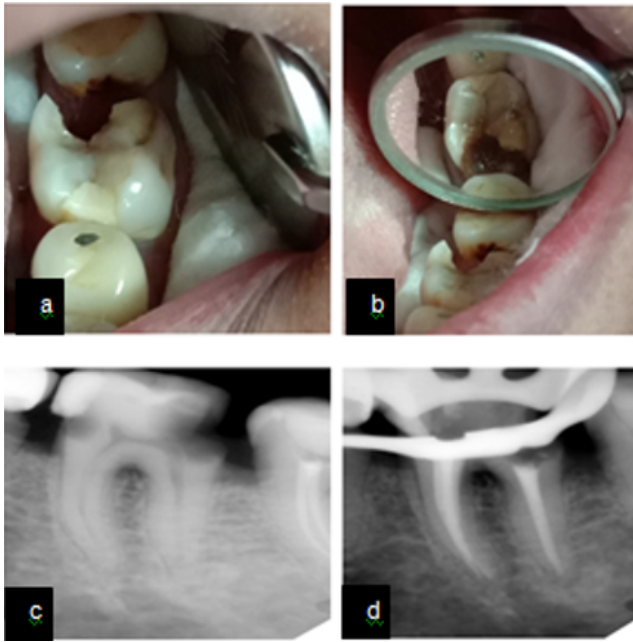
Tooth number 36 showing fractured restoration distally w.r.t 36. Caries detected below contact point of restoration on mesial aspect; a,b: Pre operative radiograph revealed radiolucency distally approximating pulp and radiolucency mesially below the restoration suggestive of secondary caries. Widening of periodontalligament w.r.t 36; c: Post obturation radiograph(d).
